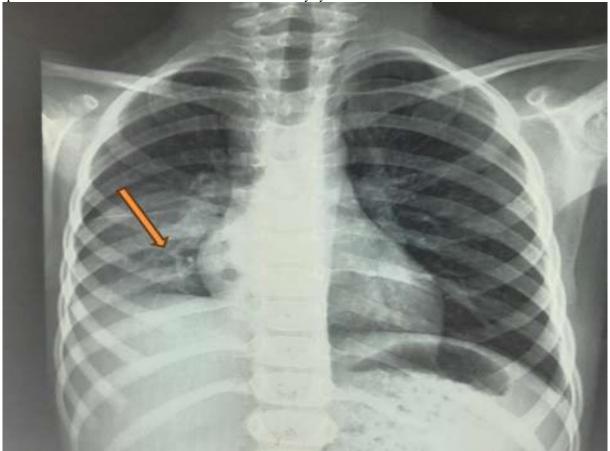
Chest X-ray (Frontal view) showing a localized pulmonary opacity in the right lower lobe.
